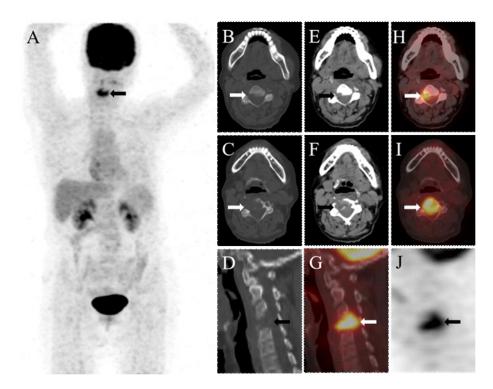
Fluorine-18-FDG PET/CT imaging: Maximum intensity projection (MIP) (A), axial and sagittal CT (B, C, D: bone window and E, F: soft tissue window), positron emission tomography/computed tomography (PET/CT) fusion (G, H, I) and PET(J) images revealed the osteolytic bone destruction of the C4 and the posterior aspect of the vertebral body of C3 with increased ¹⁸F-FDG uptake.
